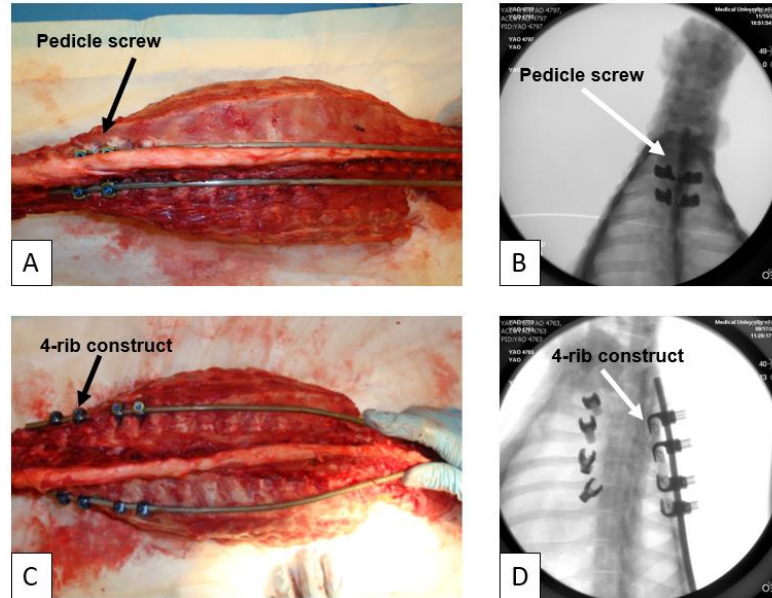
A) Growing-rod pedicle screw fixation on T3 and T4. B) Radiographic image of T3 and T4 growing-rod pedicle screw fixation. C) Rib construct fixation on ribs 3-6. D) Radiographic image of rib-hook construct. fixation (5D).
